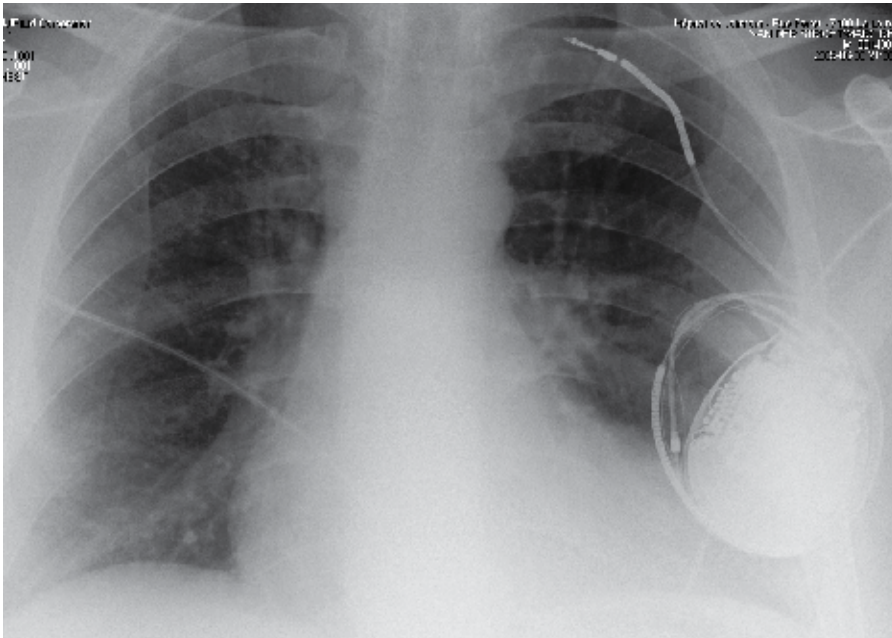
Chest X-ray showing dual-coil ventricular lead displacement, causing pectoral permanent stimulation, in a case previously reported by our team (Essoh et al, 2010). Repositioning the lead was required and successfully reported.
